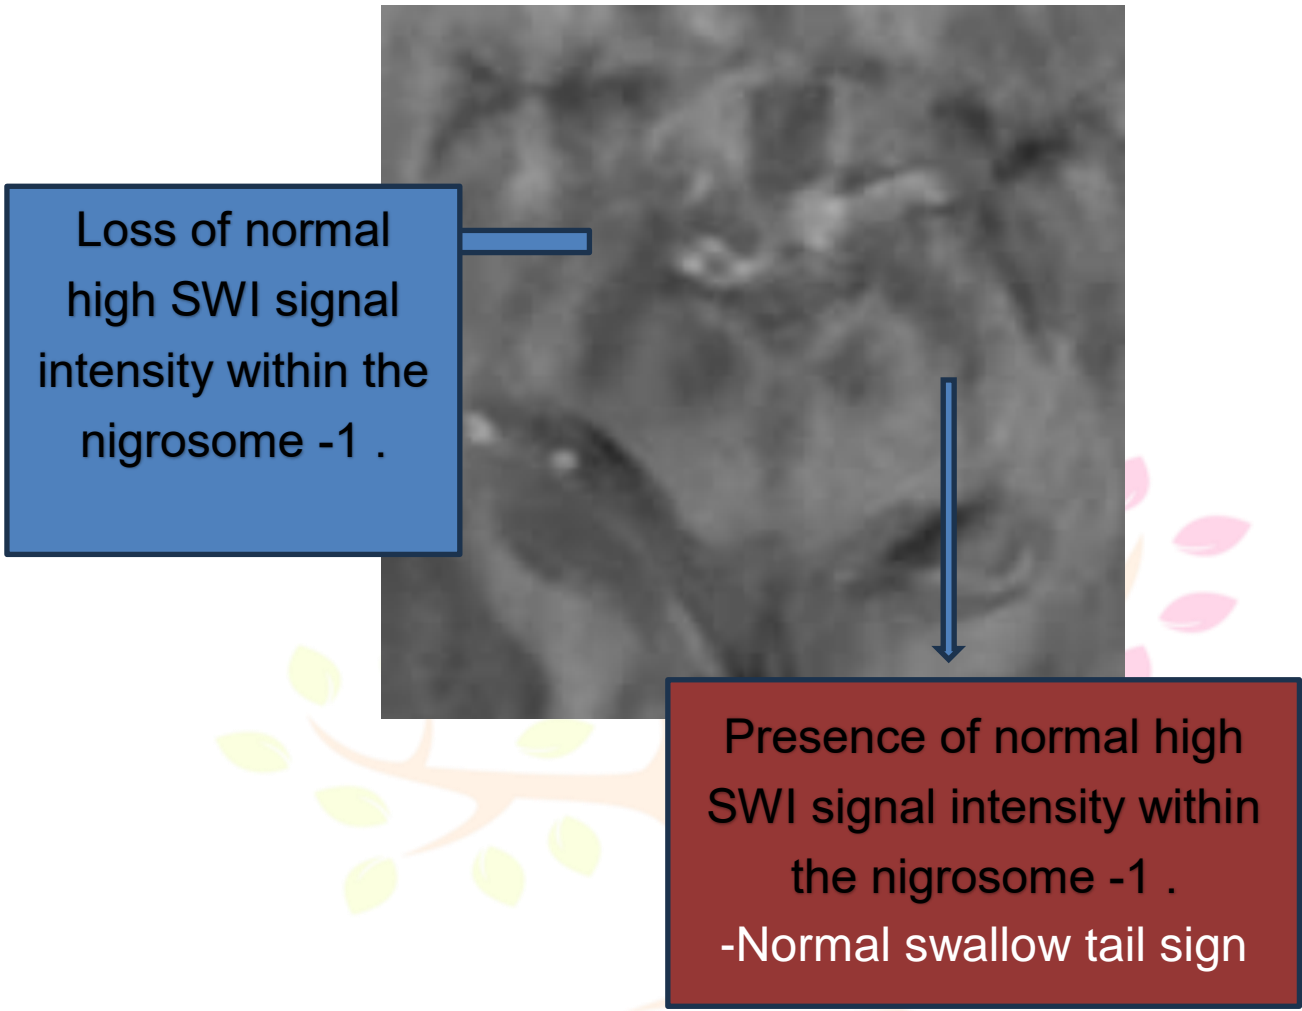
A 70 years old male patient presented with recurrent falls ,slowness of activities,resting tremors MRI Axial SWI image sequence showing loss of swallow tail sign on right side diagnosed as IPD.
